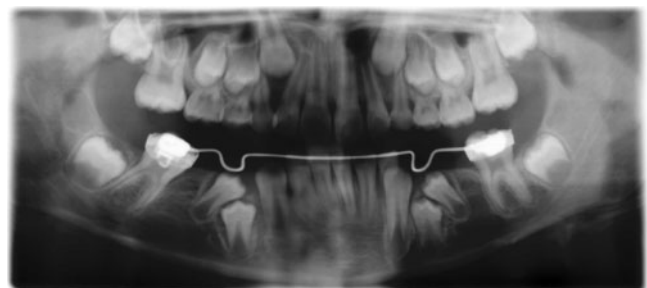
Panoramic radiograph (05-09-00)
